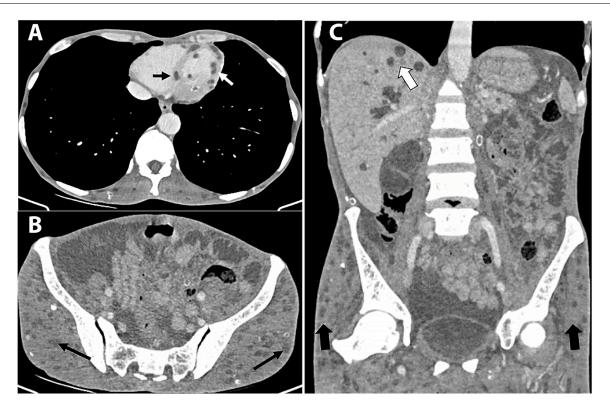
Post contrast CT images of abdomen and pelvis showing multiple granulomas in various organs: (A) In myocardium (short white arrow) and interventricular septum (short black arrow) of heart. (B) In bilateral gluteal muscles (black long arrow). (C) In liver (white boxed arrow) and muscles of pelvis (black boxed arrow).
